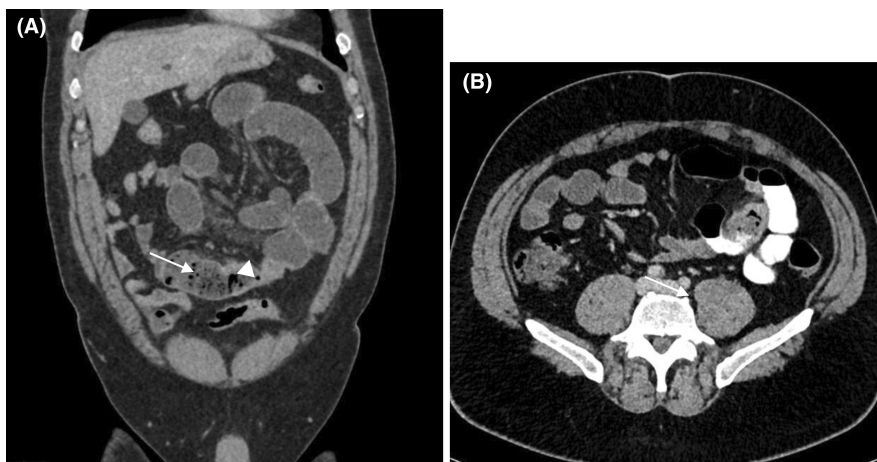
CT scan with contrast of abdomen and pelvis. (A) coronal view showing fecalization of the small bowel and dilated proximal segments (arrow), irregular wall thickening of the short segment distal ileum (arrowhead). (B) cross sectional view showing redemonstration of the irregular wall thickening of the short segment distal ileum with only partial narrowing of the lumen (arrow).
